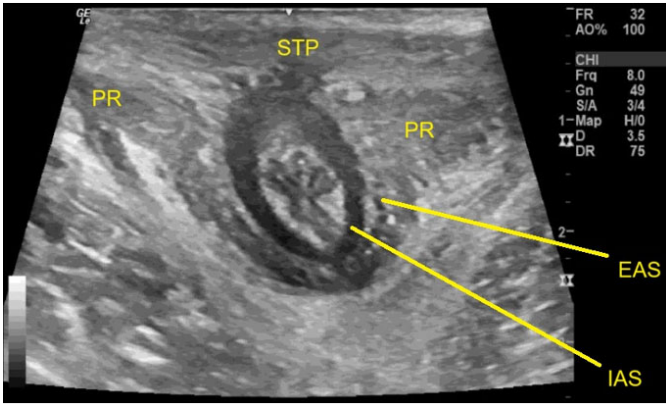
Ultrasound image of perineal adhesions causing ovoid deformity of the patient's external anal sphincter (EAS). The superficial transverse perineum (STP), puborectalis (PR) and internal anal sphincter (IAS) are labeled for anatomic clarity.
